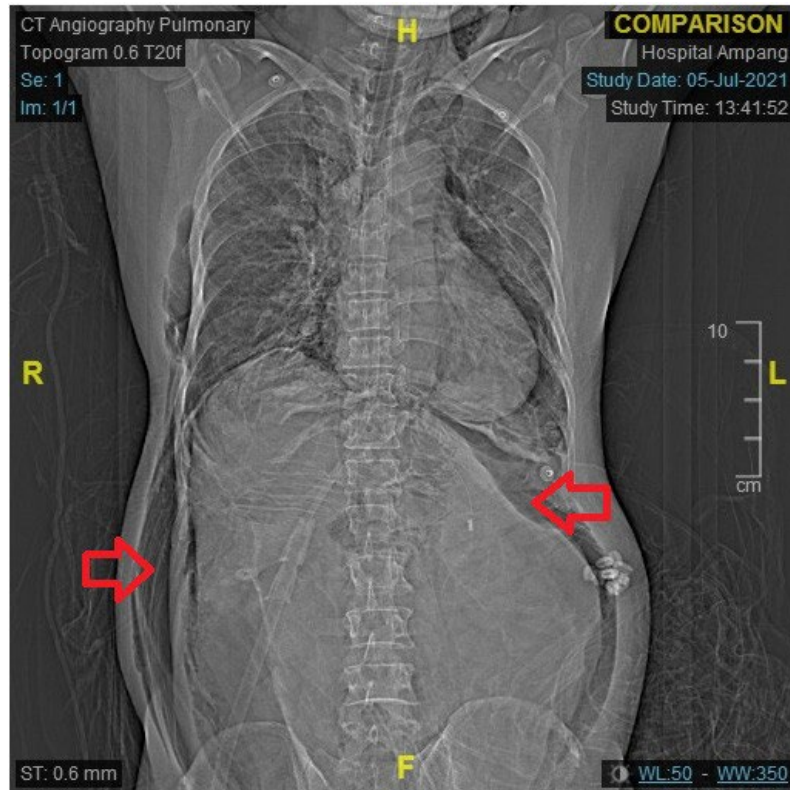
Sagittal CT revealed extensive subcutaneous emphysema with pneumomediastinum
